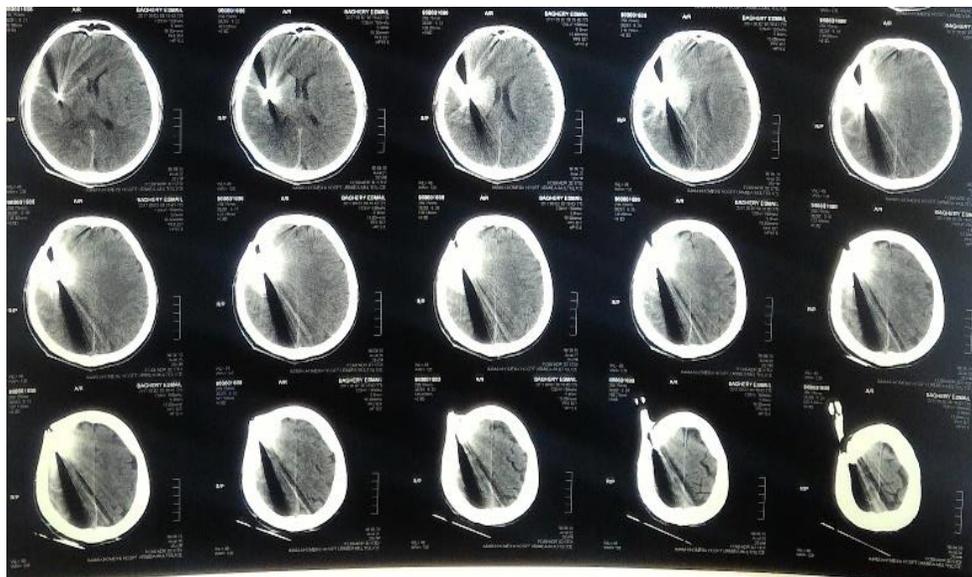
axial brain CT scan entrance and location of the stab
